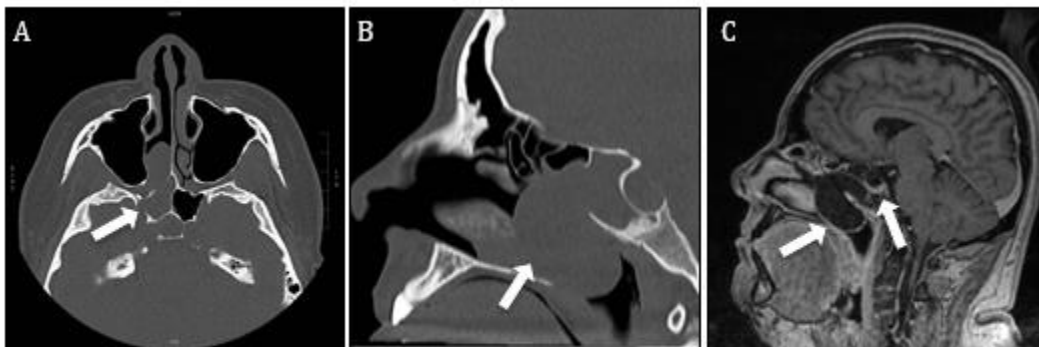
A) CT Sinuses: osseous skull base defect of sphenoid sinus. B) CT Sinuses: pseudomeningocele extending through the sphenoid sinus. C) MRI brain: partially empty sella and pseudomeningocele within the nasopharynx.
